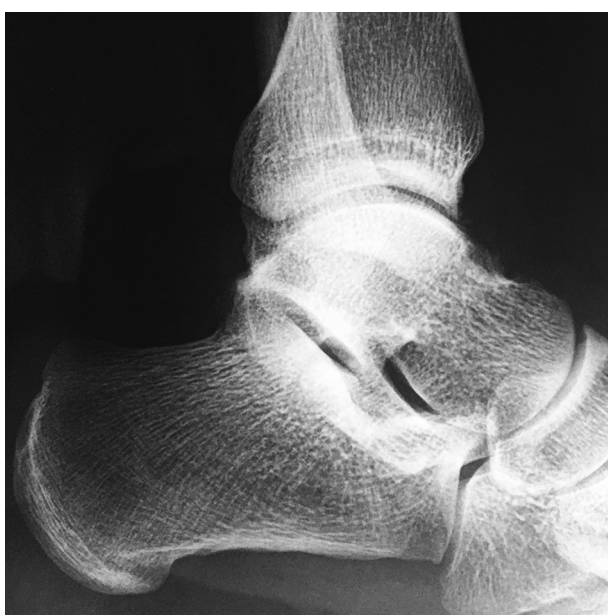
Postoperative Lateral X-ray; Proper Resection
